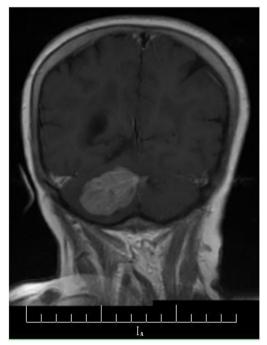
Coronal T1-weighted contrast-enhanced image. Diffuse enhancement was noted.
